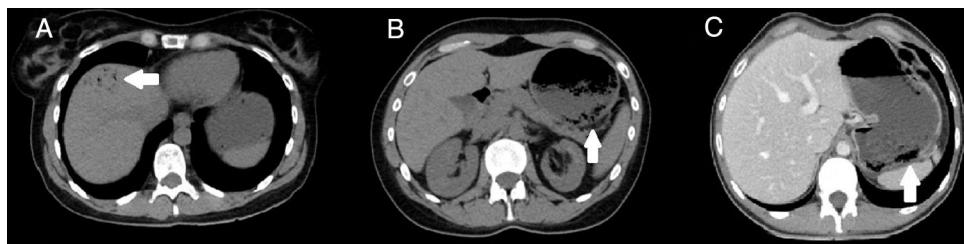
Unenhanced CT axial view showing gastric pneumatosis and portal pneumatisos (A and B). Portal phase showing gastric pneumatosis without portal pneumatisos (C).
